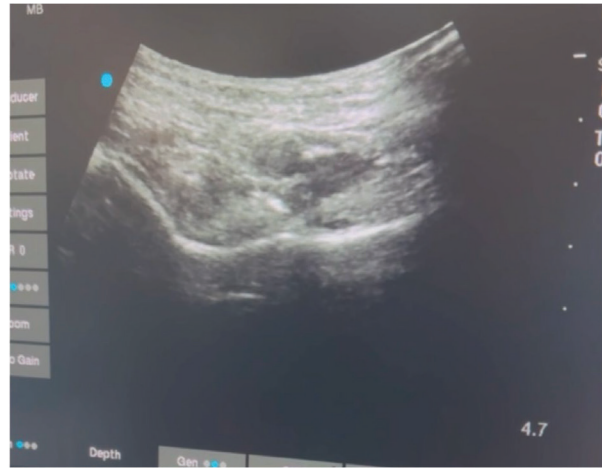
Right sided pericapsular nerve group (PENG) block and catheter placement under ultrasound guidance.
